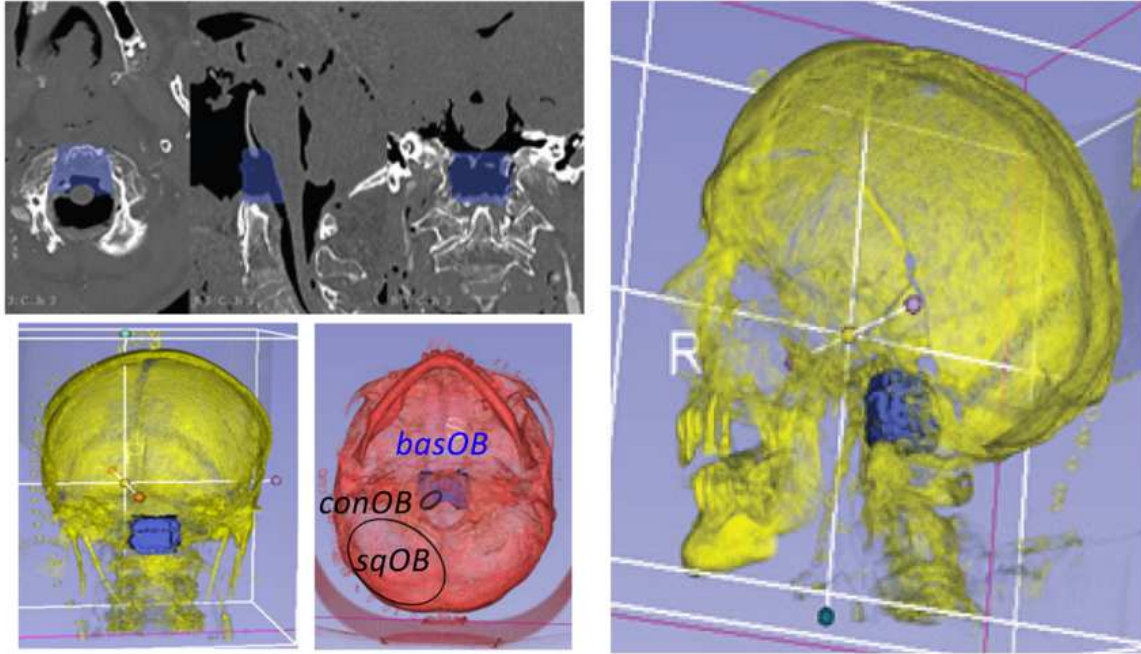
CT-scan with 3D reconstructions of the surgical volume involving the FMEA, accessing the foramen magnum anteriorly through resection of the basilar portion of the occipital bone (*basOB*) highlighted in dark blue.
